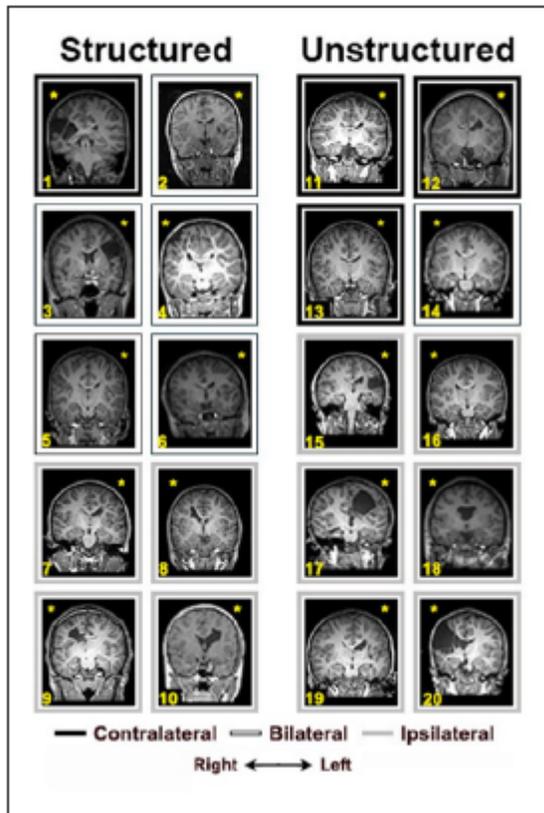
Coronal MRI slices showing a cross-section of each child's lesion. The color of the frame surrounding the MRI indicates the CST laterality of the child (black = contralateral, white = bilateral, gray = ipsilateral). The yellow asterisk indicates the side of injury.
